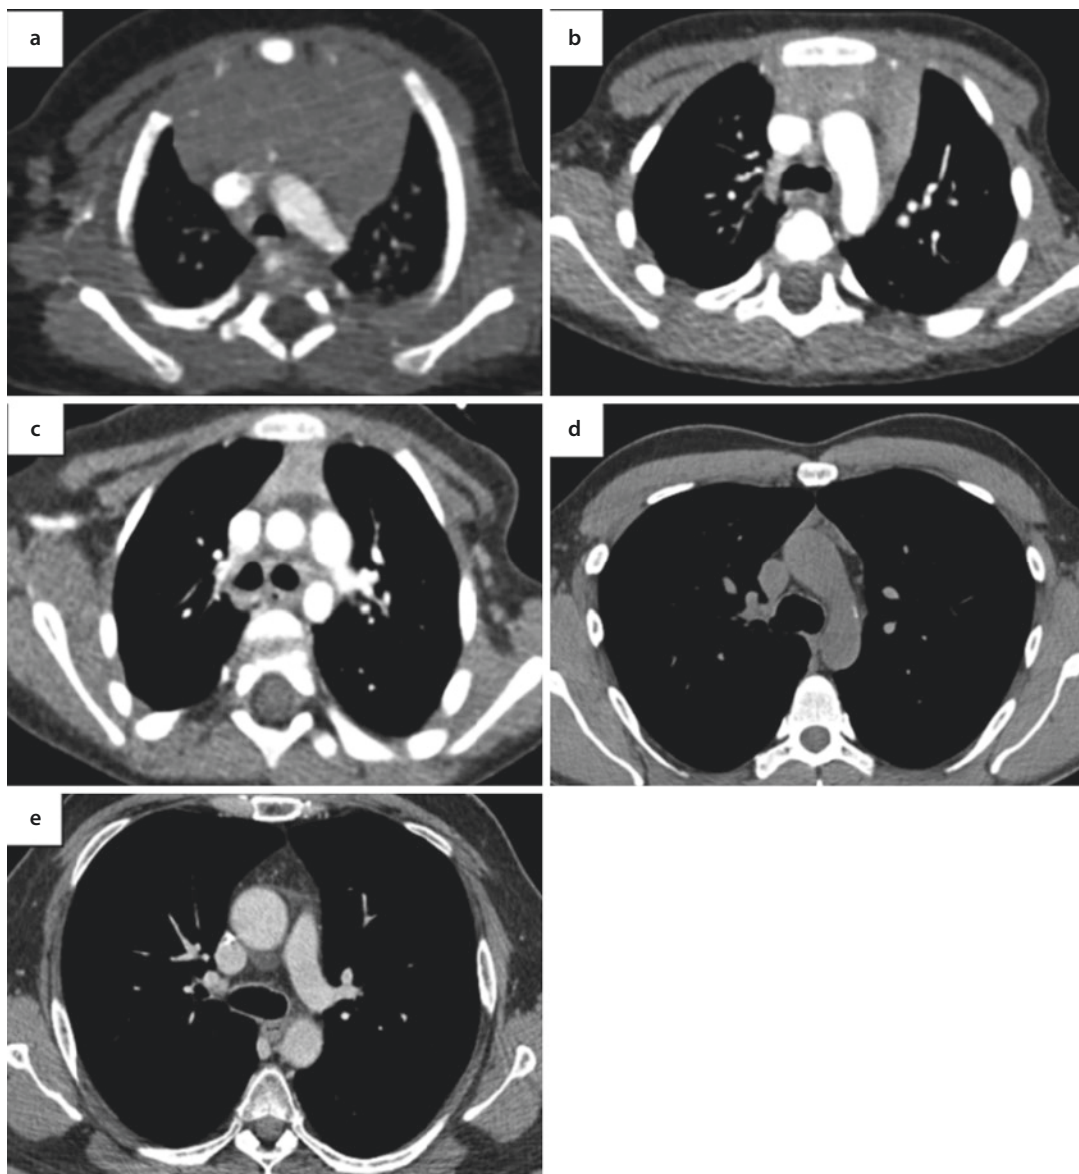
Physiological modifications of thymic morphology throughout age. Chest CT in axial plane at the age of 2 months a, 3 years b, 4 years c, 39 years d and 48 years e. a The thymus appears as a bilobed homogeneous soft-tissue density structure, without compression
